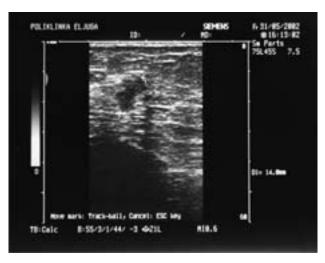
Ultrasound finding of CLI in a 52-year-old HRT user
